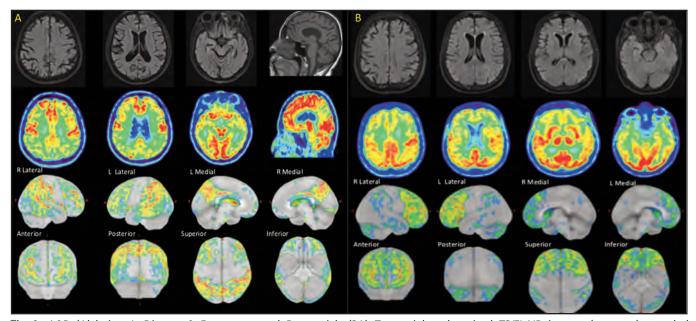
A&B (Alzheimer's Disease & Frontotemporal Dementia). (2A) Transaxial and sagittal T2/FLAIR images (top row) revealed progressive generalized cerebral volume loss, particularly in the bilateral parietotemporal regions and precuneus. Transaxial F-18 FDG PET images (second row) and Z score maps referencing the pons (third and fourth rows) showed significant hypometabolism in the bilateral frontotemporoparietal cortices, precuneus, and posterior cingulate cortices. (2B) T2/FLAIR weighted images (top row) revealed non-specific hyperintense foci in the left parieto-occipital region, suggesting small vessel disease. F-18 FDG PET images (second row) and Z score maps (third and fourth rows) showed diffuse FDG hypometabolism in the bilateral frontotemporal and parietal cortices
